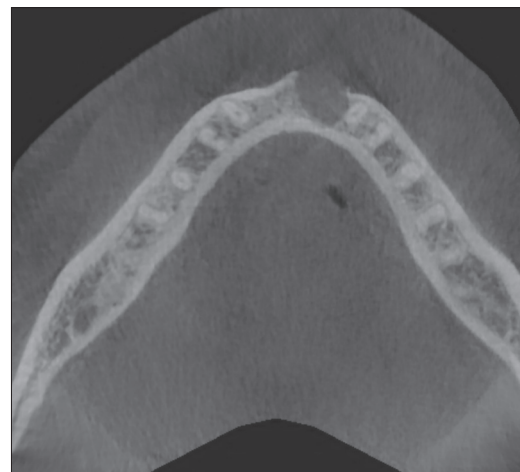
cone-beam computed tomography axial slice demonstration destruction of the facial plate related to the odontogenic cyst present
